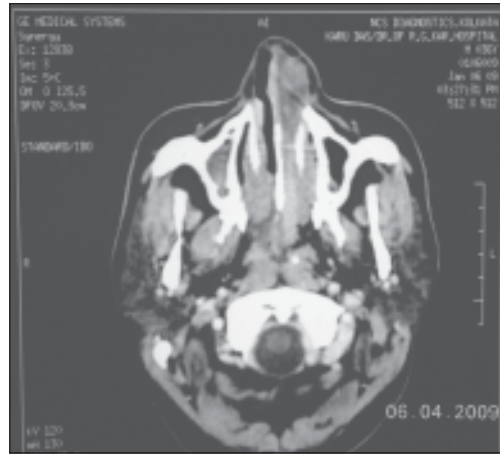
CT scan of the lesion.
